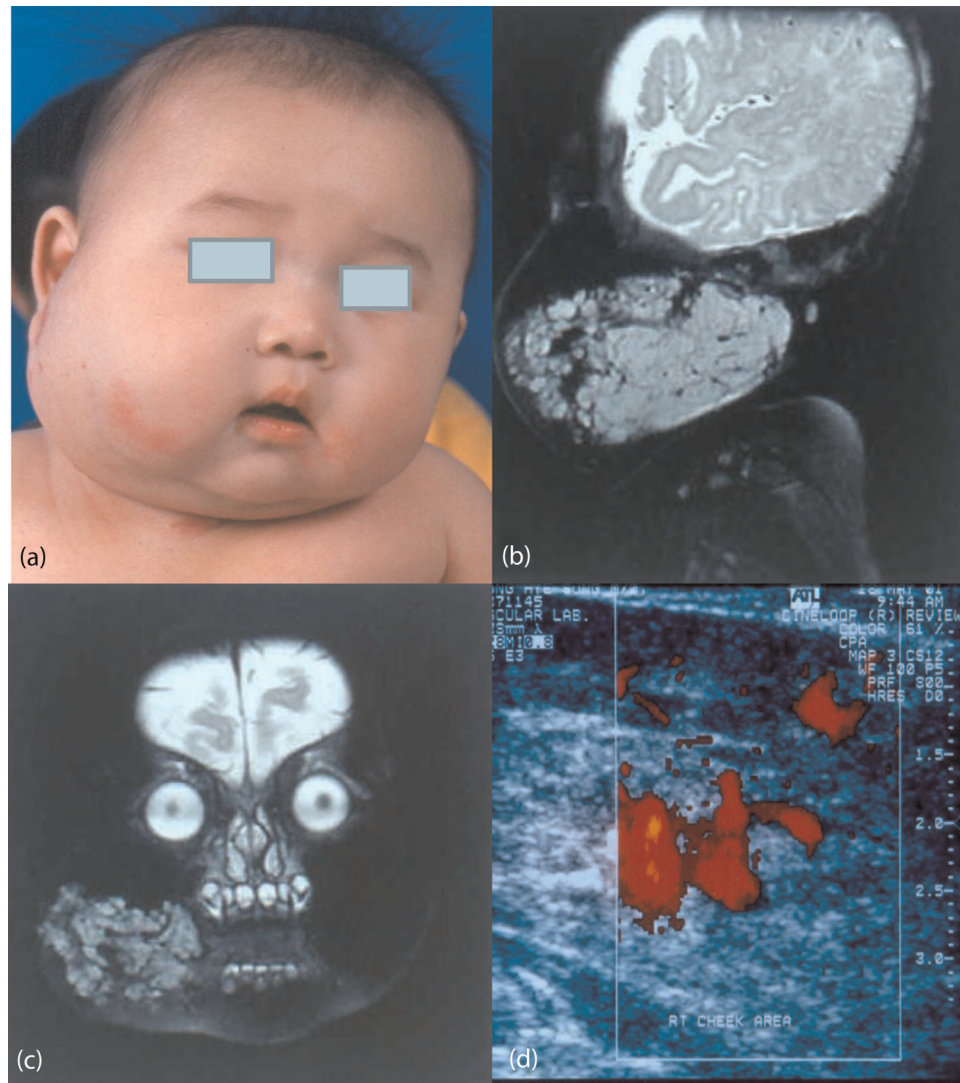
Panel depicts clinical condition of (infantile) haemangioma as rapidly expanding lesion along the right cheek, first noted a few months after birth, which may be mistaken for a venous malformation (VM). Panels b and c show typical magnetic resonance imaging findings of (infantile) haemangioma, affecting right cheek with prominent vascularity that helps differentiate it from common VM. Panel d presents duplex ultrasonographic findings of active/high blood flow through the lesion in contrast to what would be found in a VM lesion (from Lee *et al.*¹²)
